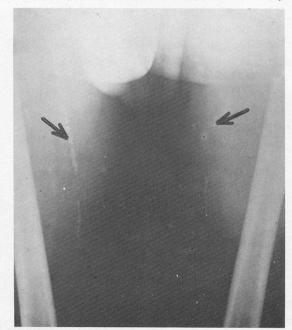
Plain X-rays of thighs in Case 1. Arrows indicate calcification in femoral arteries.
